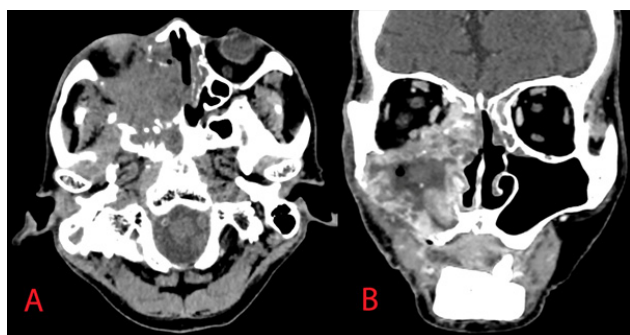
Contrast-enhanced CT paranasal sinuses of axial (A) and coronal (B) section showed heterogeneous enhancing mass had invaded almost all the bony structure in right oral, nasal cavity, paranasal sinuses as well as the right orbit.
